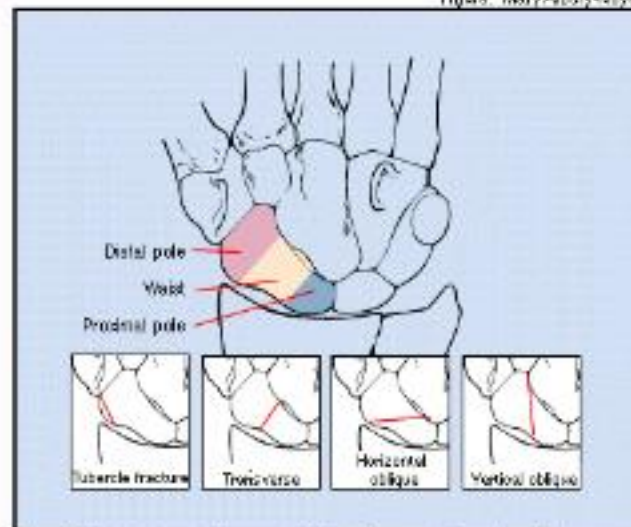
A dorsal view of the scaphoid bone demonstrates various fracture orientations. Determining the orientation on radiographs is important because the orientation helps guide treatment decisions.
